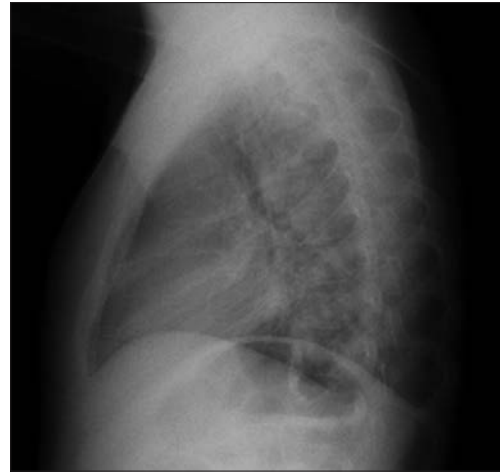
Lateral chest X-ray after the operation viewing improved sternum
